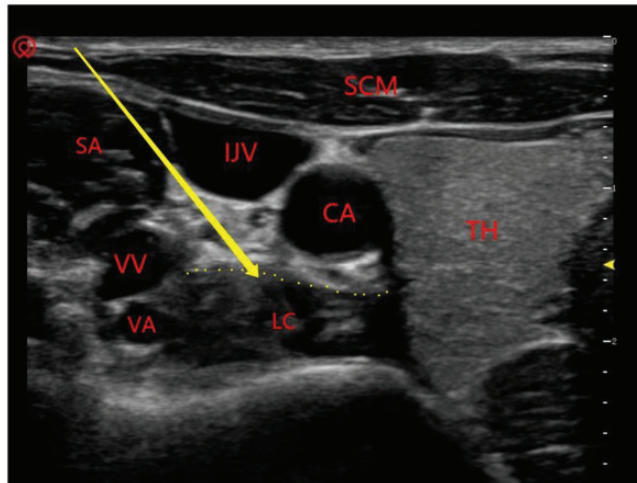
Stellate ganglion block site under ultrasound guidance. SCM: sternocleidomastoid muscle; TH: thyroid; CA: carotid artery; IJV: internal jugular vein; VV: vertebral vein; VA: vertebral artery; LC: longus colli; SA: scalenus anterior. The yellow arrow represents the direction and depth of the needle. The yellow dotted line represents the lamina profunda fasciae colli.
